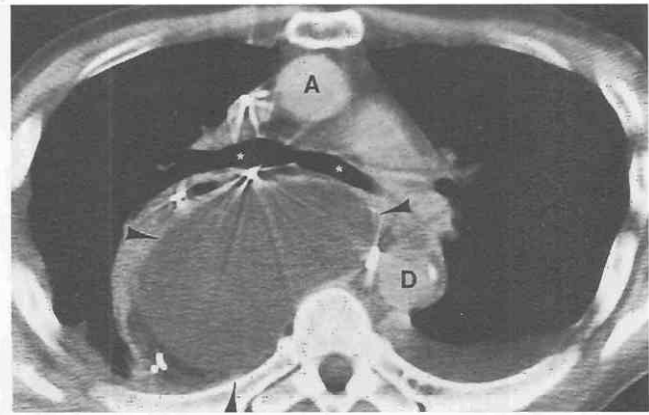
Thoracic lymphocele after esophageal resection and gastric pull-through. Contrast-enhanced CT shows large homogeneous fluid collection (arrowheads) in middle/posterior mediastinum displacing tracheal carina (asterisks) anteriorly and gastric pull-through anterolaterally. A, ascending aorta; D, descending aorta.
